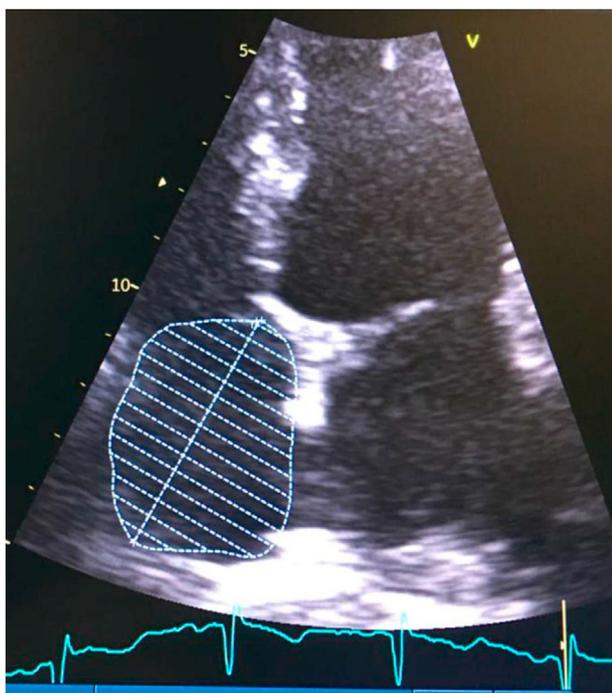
Measurement of right atrial volume in apical 4 chamber view.
